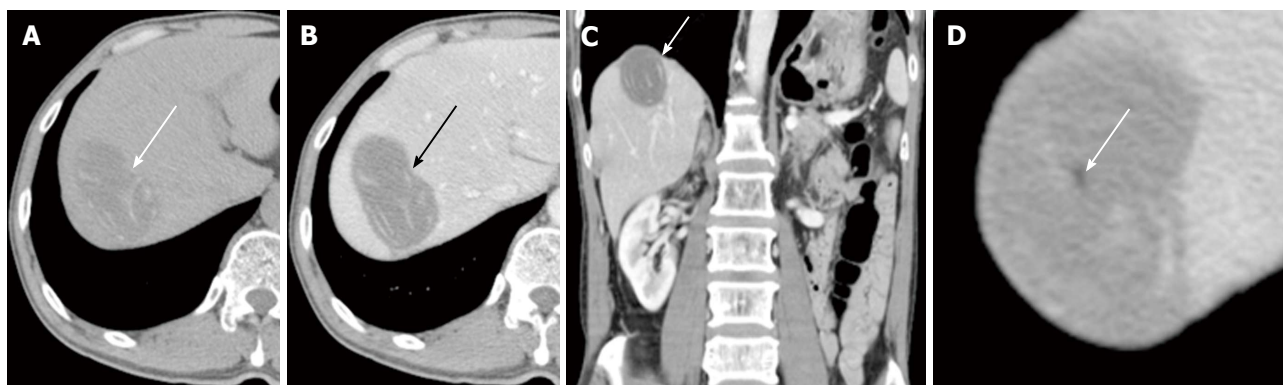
Liver computed tomography imaging. A: Axial noncontrast computed tomography (CT) image showing an ovoid low attenuation lesion (arrow) in the right hepatic dome. This mass has internal linear or curvilinear cord-like lesions that are most likely calcified. This mass (arrow) measured 6.3 cm × 3.5 cm. B: Axial contrast-enhanced CT image clearly showing that this ovoid lesion (arrow) does not have any enhanced portions, which suggests a totally necrotic lesion or a cystic mass. The internal cord-like structures are bizarrely arranged; C: Coronal contrast-enhanced CT image showing that the internal structures within the mass (arrow) are arranged in a whirling manner; D: Low attenuation (-22 Hounsfield units) region (arrow) in the center of the mass on a contrast-enhanced CT image, suggesting the presence of a small amount of fat.
